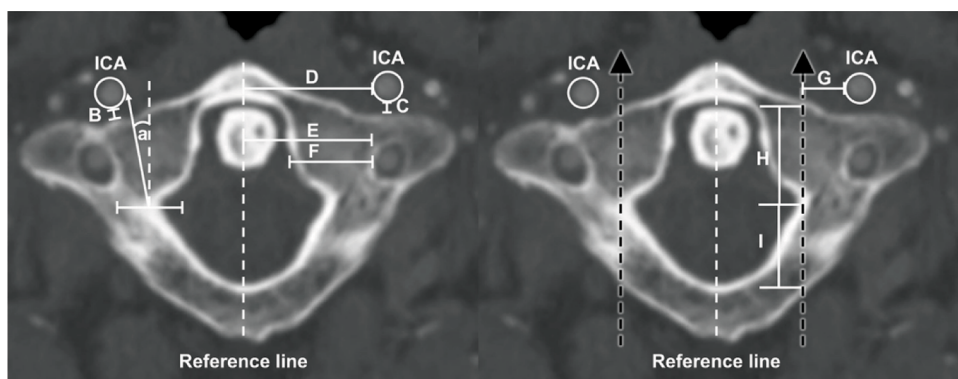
Measurement from axial CTA carotids at the C1 vertebra level. The ICAs are indicated by circles. A reference line (Ref) from the anterior to posterior tubercles (white dashed line) parallels the anticipated screw trajectory, bisecting the posterior cortex of the lateral mass (LM) (black dashed arrow). Angle a represents the angle between ICA and the screw trajectory. B measures the distance from the ICA to the anterior cortex along angle a , while C represents the minimum distance to the nearest cortex. From the Ref, D measures the distance to the medial wall of the ICA, while E measures the distance to the transverse foramen. F measures the width of the LM. G measures the distance from the screw trajectory to the medial wall of the ICA. H measures the screw trajectory distance within the LM, while I measures the trajectory's distance to the posterior cortex of the posterior arch.
